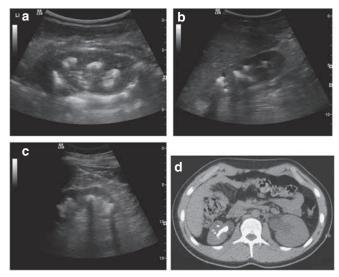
Radiographic findings in PH. (a-c) Typical sonographical and X-ray findings of severe urolithiasis in patients with primary hyperoxaluria (PH) type I aged 5, 9, and 39 years and with still normal or only slightly impaired renal function. (d) Low enhanced computed tomography scan showing a Staghorn calculus and five further smaller stones in the right kidney of a 16-year-old patient with PH, uncompliant with regard to medication and fluid intake.
